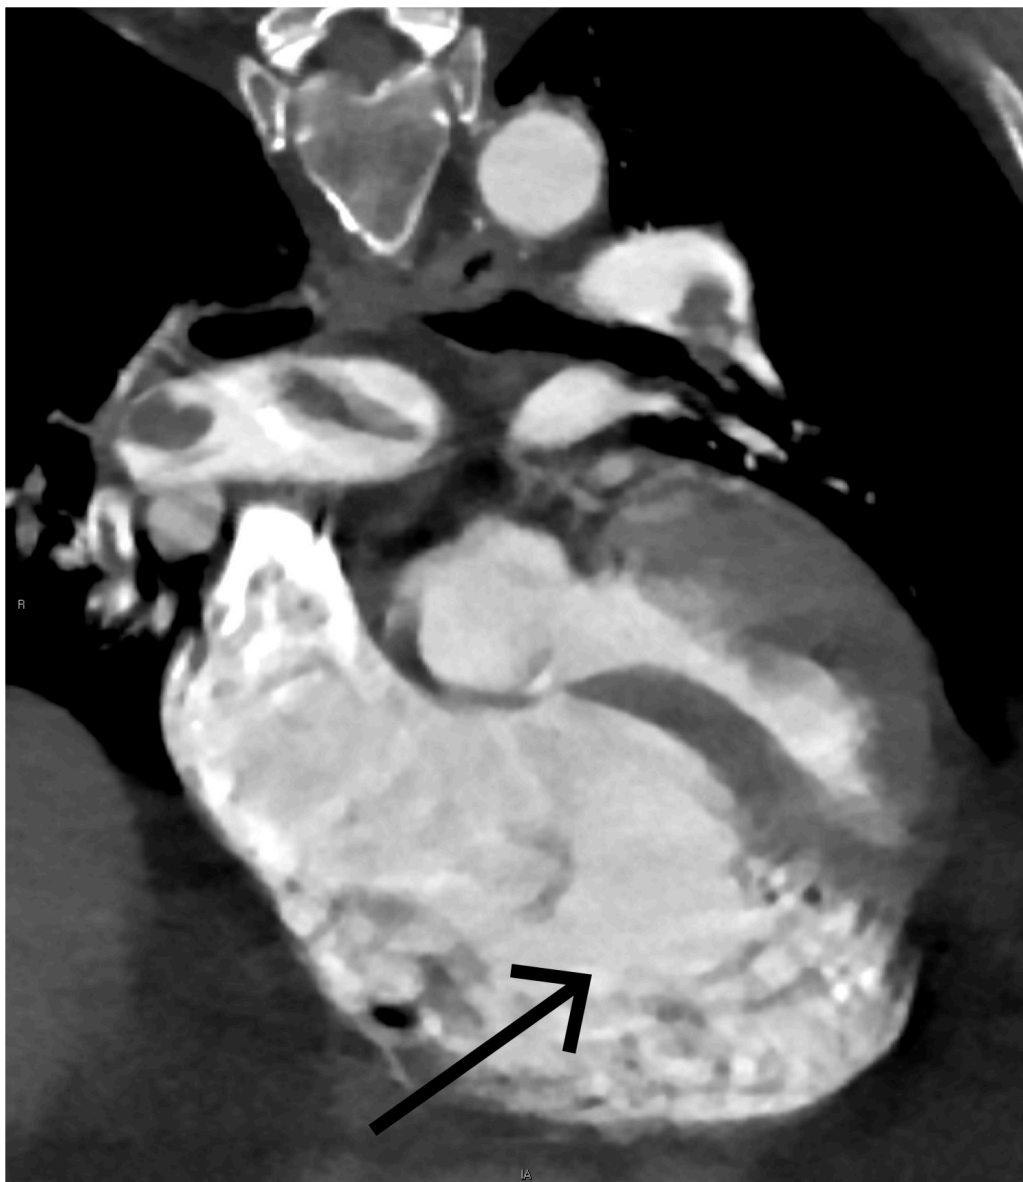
Dilated right heart chambers shown on CT angiography.
